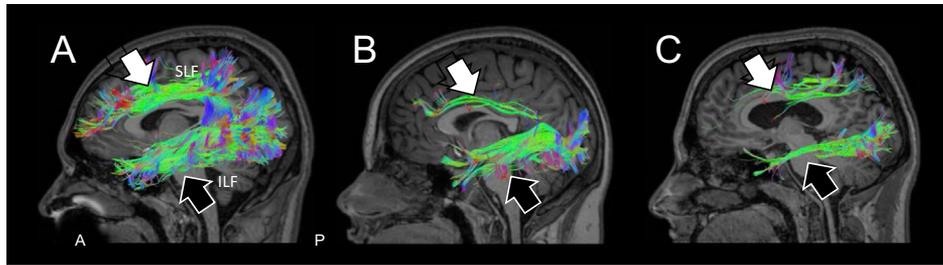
Sagittal view of white matter tractography of the dorsal and ventral visual processing streams is revealed with diffusion MRI (HARDI). “Virtual dissection” allows for the reconstruction of the superior longitudinal (SLF) and inferior longitudinal (ILF) fasciculi (corresponding to the neuroanatomical correlates of the dorsal or spatial and ventral or object visual processing streams, respectively). The fasciculi were reconstructed by seeding the occipital pole. Similar patterns of white matter tractography emerged from both hemispheres in each individual, so reconstruction in only the left hemisphere is shown for simplicity. (A) Reconstruction of the 2 fasciculi in a normally sighted control (18-year-old boy; no history of visual dysfunction). Note the robust appearance of the SLF (white arrow) and ILF (black arrow). (B) Reconstruction of the same 2 fasciculi in an individual with CVI with spatial processing deficits (14-year-old boy; 20/25 is standard Snellen clinical notation visual acuity). Note the dramatic reduction in the structural integrity of the SLF consistent with spatial processing deficits. (C) Reconstruction in a second individual CVI (20-year-old boy; 20/25 is standard Snellen clinical notation visual acuity) with observed deficits in both spatial processing and object recognition. Note the corresponding reduction in structural integrity of both the SLF and the ILF, respectively. Color scheme same as presented in Figure 1. (Modified with permission from Bauer et al.⁷³) (Color version of figure is available online.)
